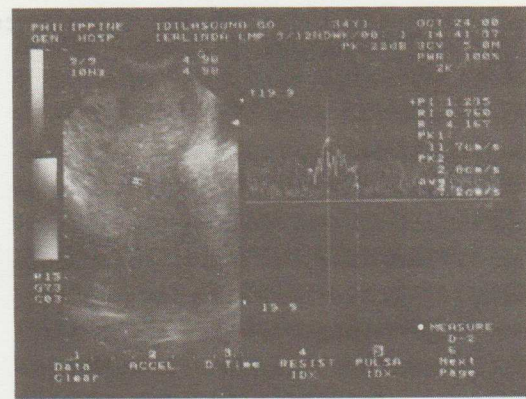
Doppler studies show a vascular mass with PI = 1.235, RI = 0.760.
